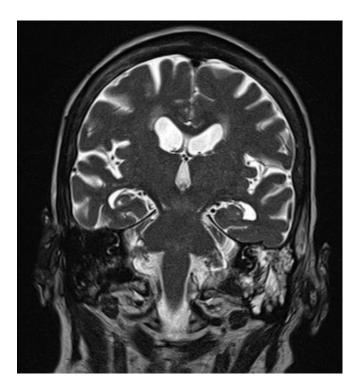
T2 TSE coronal MRI image of the brain and temporal bones.
